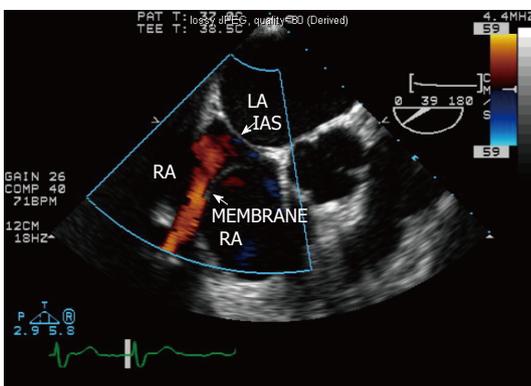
Color flow Doppler demonstrating the partially obstructive nature of the membrane, with blood flow through a small connection in the superior portion of the right atrium between the two chambers. IAS: Interatrial septum; LA: Left atrium; RA: Right atrium.
